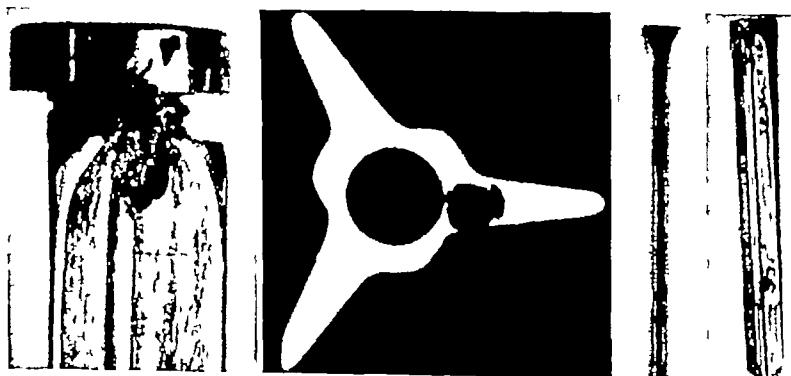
Photograph, roentgenogram, and cross section of rustless steel nail removed by Otto Raagaard. Electrolytic destruction of metal and bone caused nail to loosen sufficiently to prevent union of fracture.
